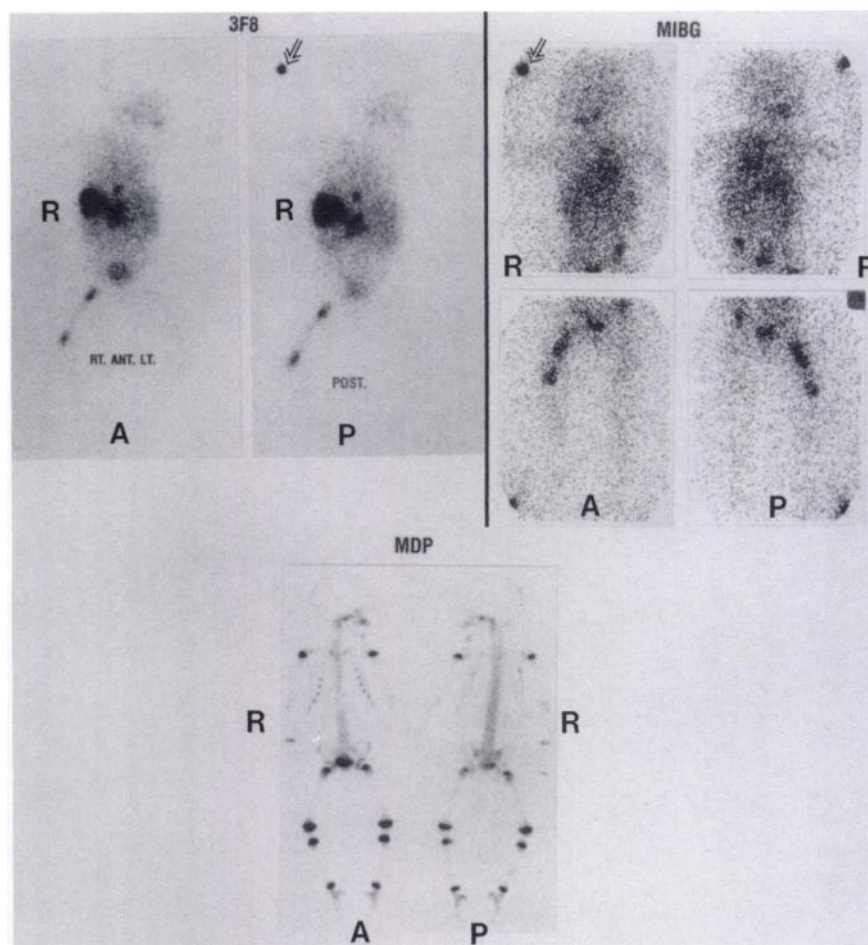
Patient 10: ^{131}I -3F8 imaging showed increased uptake in the lower portion of the right lobe of the liver, multiple areas in the mid- and lower thoracic spine, and right proximal and distal femurs. The large hepatic lesion was also found in CT, MRI, and $^{99\text{m}}\text{Tc}$ -sulfur colloid liver scan (data not shown). The [^{131}I]MIBG showed increased uptake in the right femur, left iliac bone, and right renal fossa but not the large tumor behind the liver. The MDP bone scan appeared normal. Anterior view (A) is on the left and posterior view (P) is on the right.
